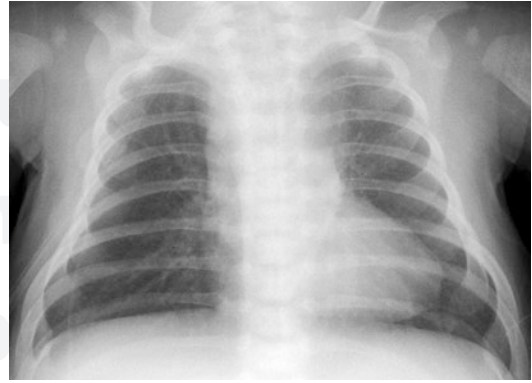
Six-week-old female patient with uncorrected TOF. Frontal chest X-ray taken preoperatively, showing a boot-shaped appearance of the heart with elevated left ventricular apex
